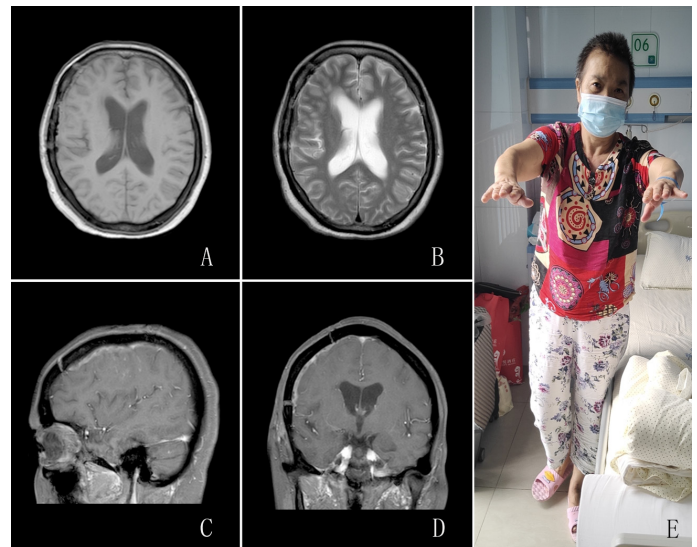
(A) T1-weighted MRI (B): T2-weighted MRI (C&D): Enhanced MRI. At the two-month follow-up, the patient's myodynamia of the left limbs had gradually improved (E).
